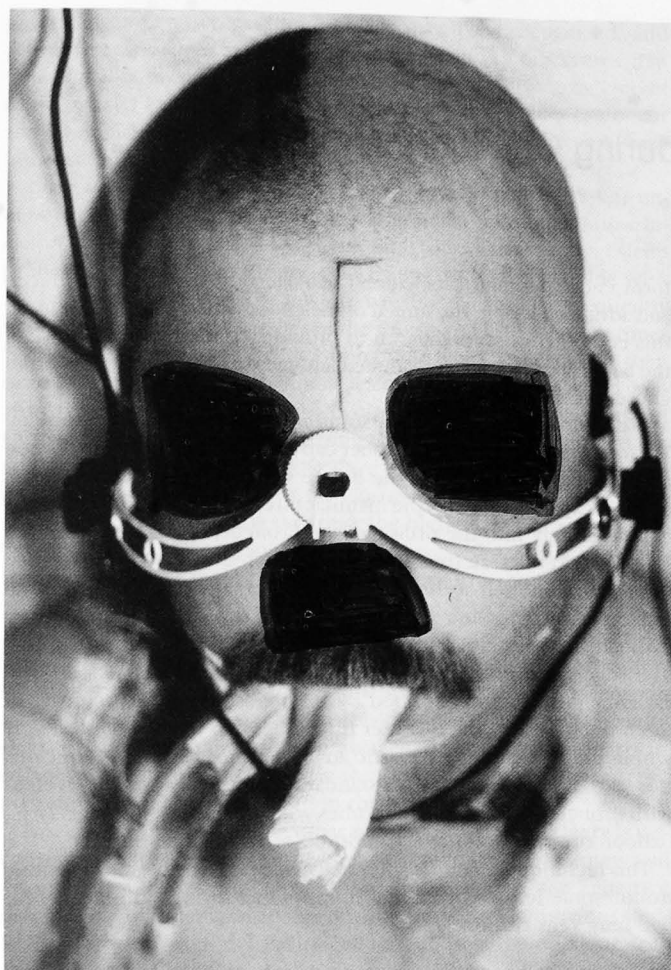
The fixation frame viewed from above. The ear inserts and the foam-padded nose rest are used to anchor the frame without interfering with the potential surgical field. The adjustable Doppler transducers are mounted on the side-arms.
